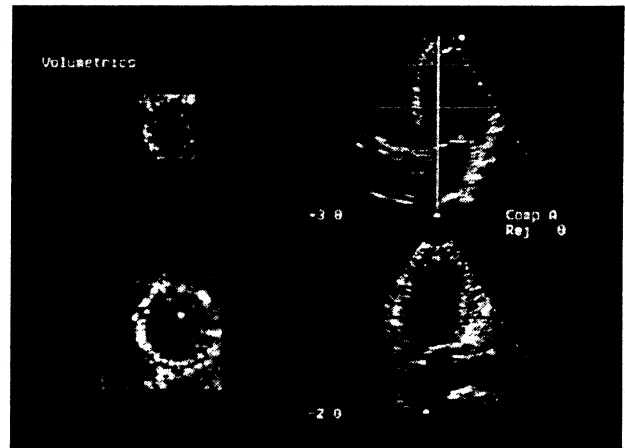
Visualization of data on the real-time volumetric ultrasound imaging system
